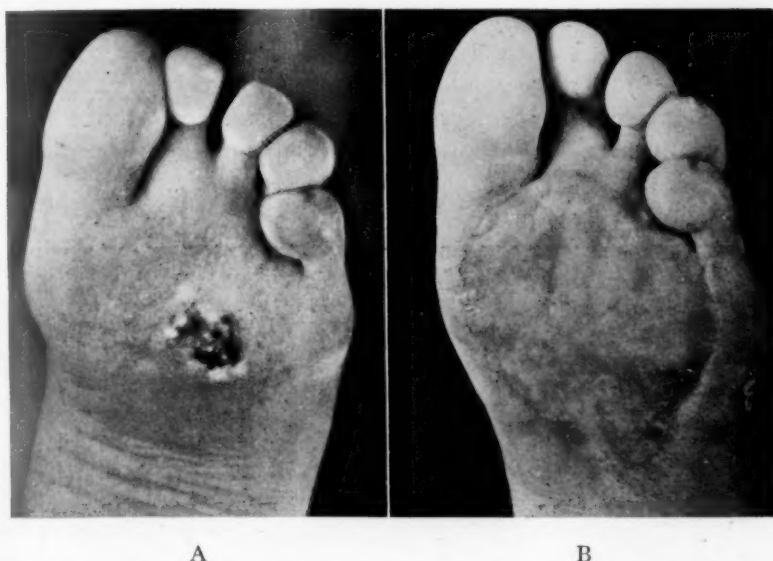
(A) Extensive change following roentgen ray treatment for plantar wart, with carcinoma having been removed previously from the burn. (B) Result of wide deep excision and repair with thick split graft; one operation. When there is sufficient soft tissue pad on the sole, free grafts can be used. Otherwise, pedicle flaps are required.
